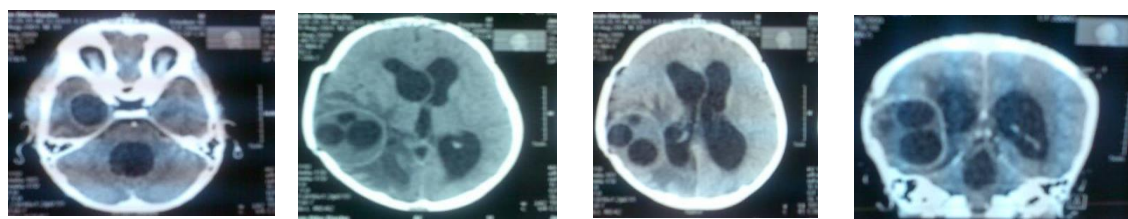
(case 2). CT scan pictures showing recurrent CHCs due to inadvertent rupture of the initially presenting single right parietal HC: a. Axial view showing HC in right temporal lobe and in the fourth ventricle. b and c. Axial view showing HCs in right parietal lobe. d. HCs in the coronal view.
